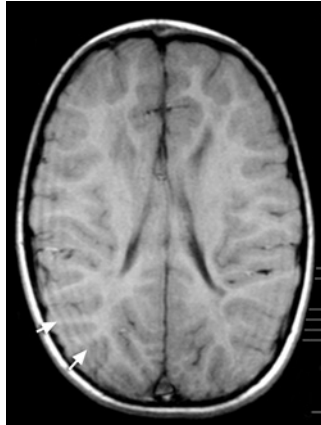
Truncation artifacts: T1-weighted axial image of the brain shows dark linear artifacts along the periphery of the brain (arrows). These lines disappeared with increased matrix
